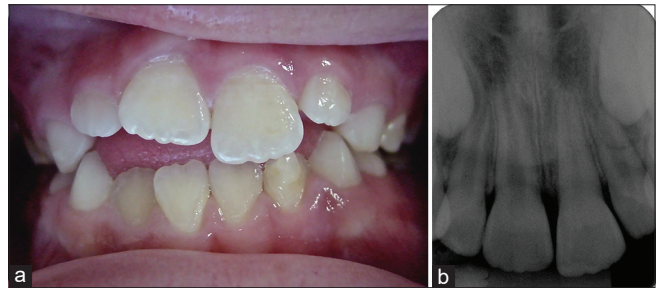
(a) Clinical appearance at 8 months. (b) Eight-month radiographic appearance
